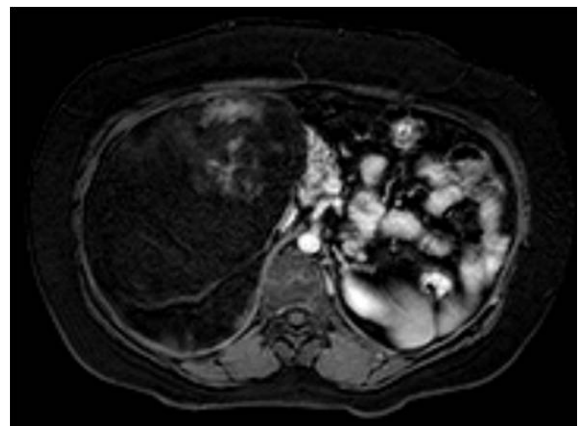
In axial fat-saturated gadolinium-enhanced T1-weighted gradient-echo abdominal MR image; show low signal intensity (reflecting the presence of fat) and show areas of contrast enhanced areas reflecting hematopoietic tissue or hemorrhage.
